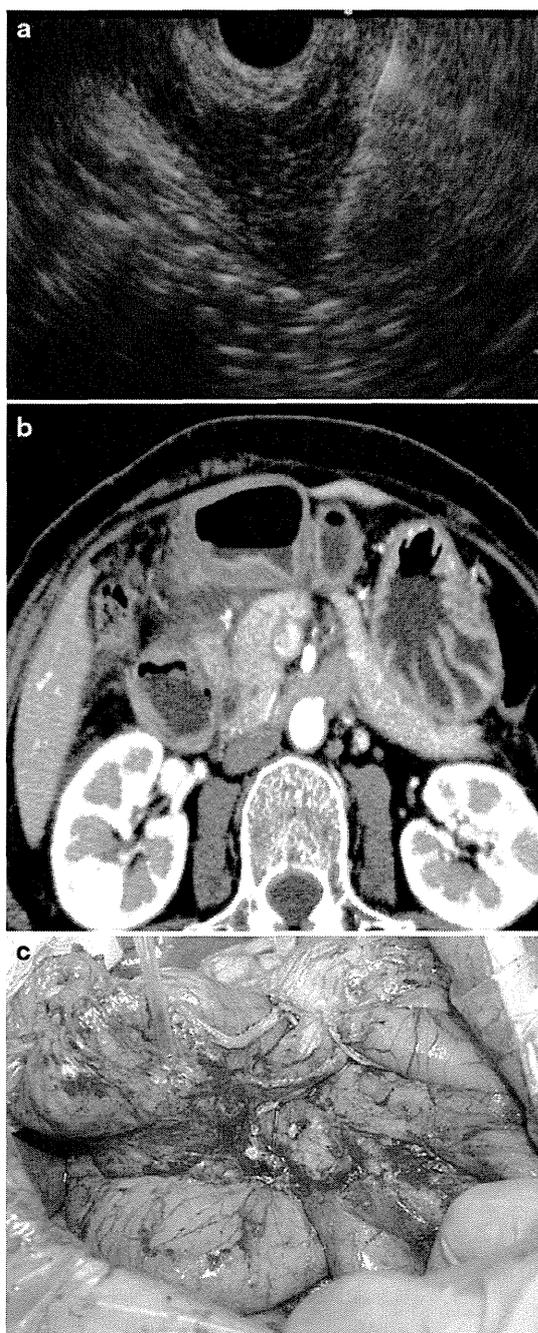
A case of pancreatitis after EUS-FNA. a FNA was performed using 22-gauge needle. b Abdominal CT revealed fluid collection around the pancreas head. c The intraoperative findings revealed a blood clot around the pancreas head lesion, and adhesion was confirmed between the pancreas head and the duodenal wall
